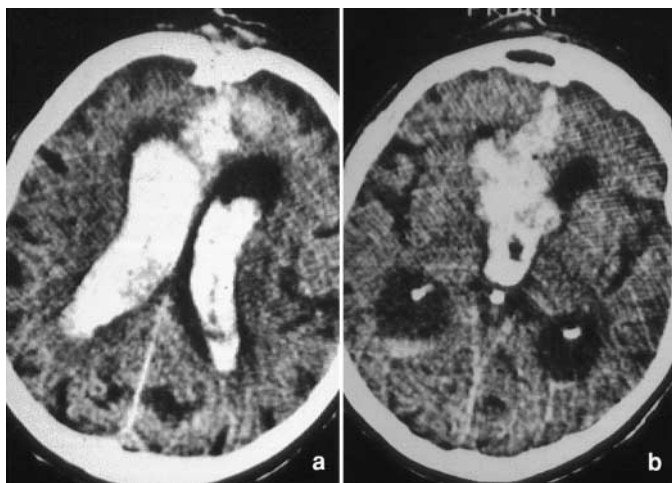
(a) Brain CT scan shows a displaced bone fragment at the forehead entry site. The wound canal is extending into the lateral ventricles, causing intraventricular haemorrhage. (b) Brain CT scan at a lower level again shows the wound canal, with a large bone fragment at the end of the canal in the posterior aspect of the third ventricle, just anterior to the calcified pineal gland
